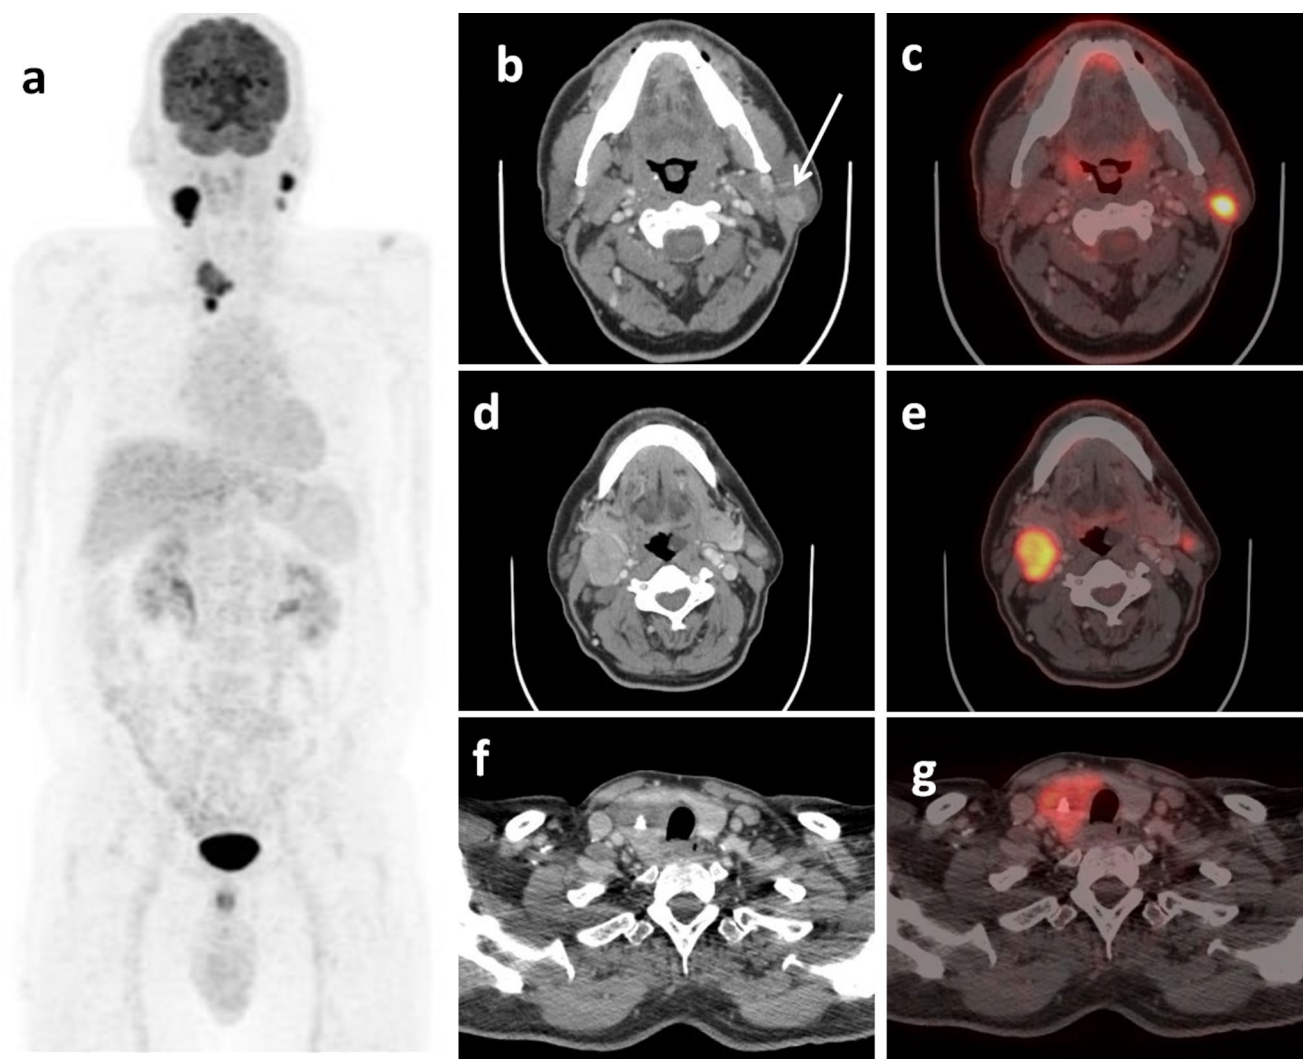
Shows maximum intensity projection (MIP) image (a), axial sections of CT and fused PET/CT (b-g) showing FDG avid soft tissue nodule in left parotid gland (SUVmax-14.17) (white arrow), FDG avid bilateral cervical lymph nodes, largest right cervical lymph nodal
